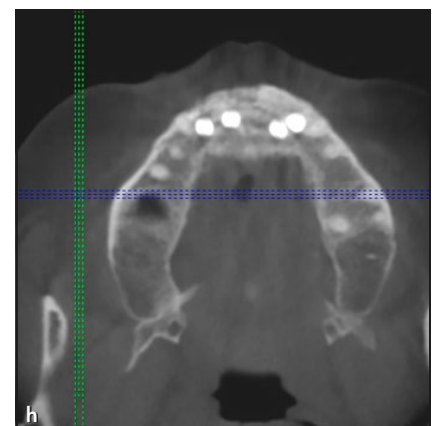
Clinical and radiographic appearance at 2 years postoperative. (a) Frontal view. (b) Periapical radiographs of maxillary fixtures. (c) Maxillary right lateral incisor (CBCT). (d) Maxillary right central incisor (CBCT). (e) Maxillary midline (CBCT). (f) Maxillary left central incisor (CBCT). (g) Maxillary left lateral incisor (CBCT). (h) CBCT of maxilla showing the facial contour of the anterior maxilla.
